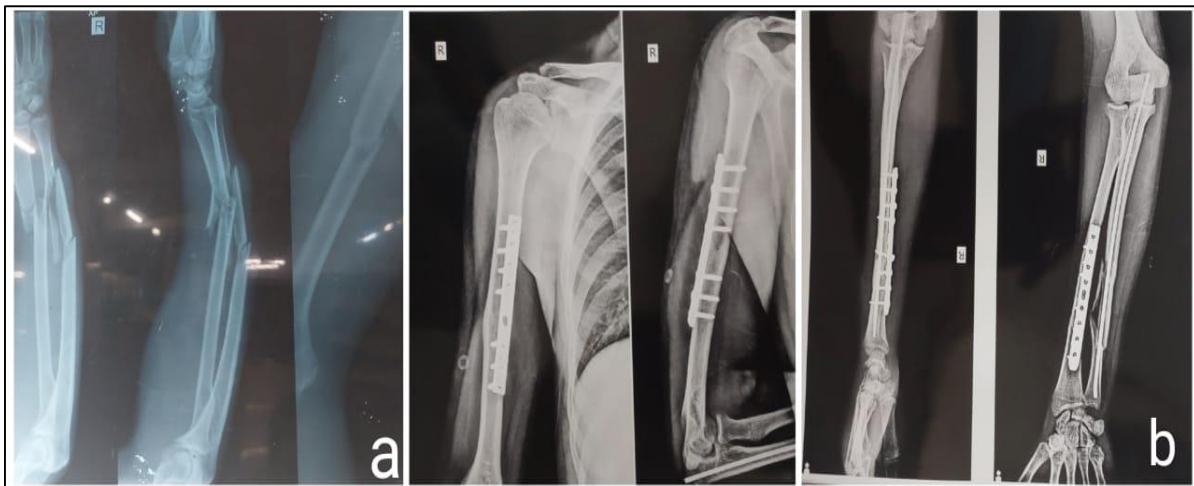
(a) Pre-op x-ray shows both bone fracture of three parts and midshaft fracture of the humerus (b) post-op x-ray: shows the internal fixation of the fractures with plating and screws.
